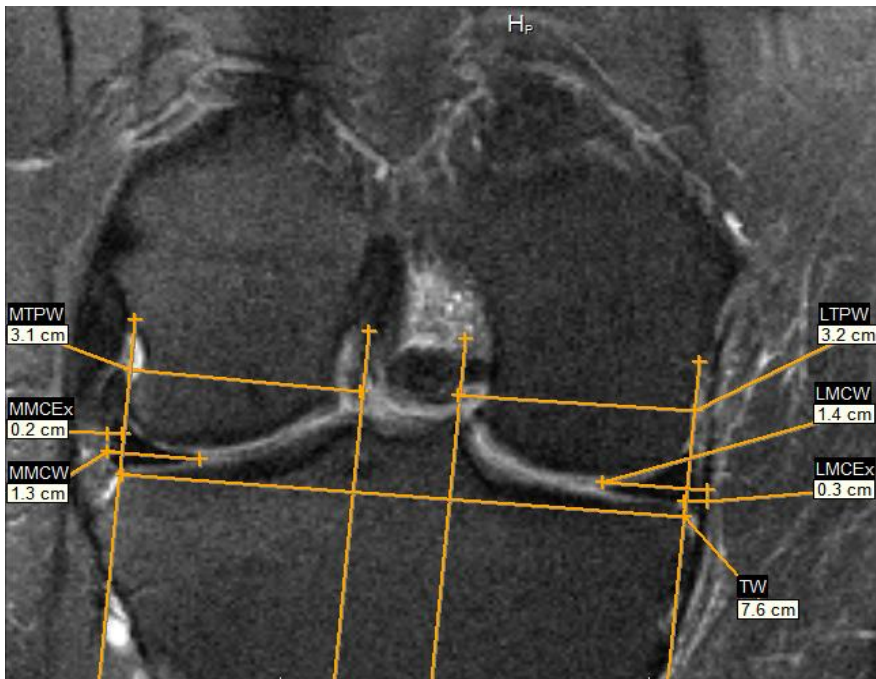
Method for measurements on MRI in all four papers.
